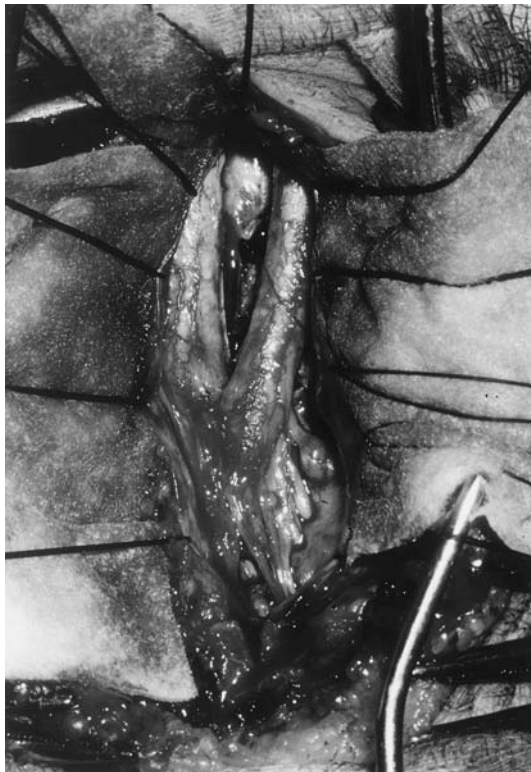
a Type I split cord malformation at operation. The two dural tubes containing the hemicords unite just below the dividing spur, with associated nerve roots visible. b Type II split cord malformation. Two hemicords visible within a single dural tube on CT myelography. The lateral nerve roots are well seen.
